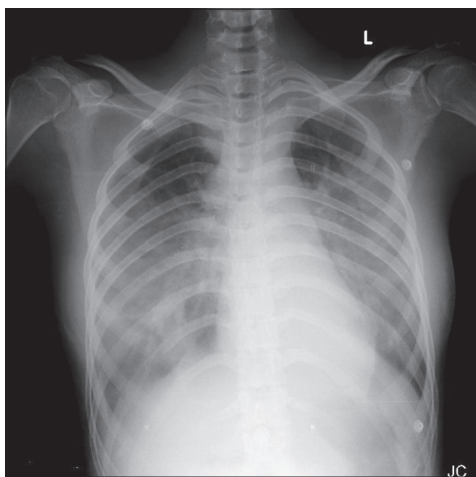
Chest X-ray showing bilateral extensive inhomogeneous shadows involving the middle and lower zones of both lung fields, with sparing of both upper zones
